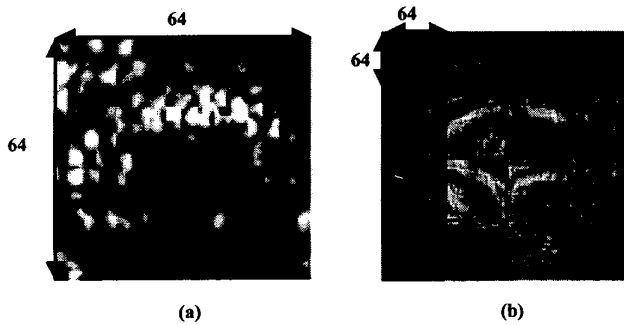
(a) Original cardiac ultrasound slice. (b) Real part of coefficients for a 16-quadrant tiling of the Fourier plane in the overcomplete case.
